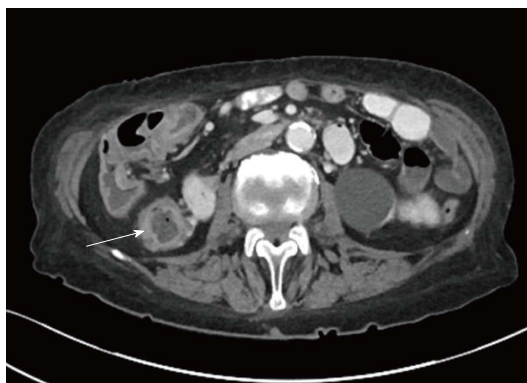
Axial image from computed tomography Chest/Abdomen/Pelvis performed with intravenous (IV) and oral contrast showing non-specific colonic wall thickening in the ascending colon (arrowed) and hepatic flexure characterised by discontinuous mucosal hyperenhancement and submucosal oedema reflecting ulceration and inflammation.
